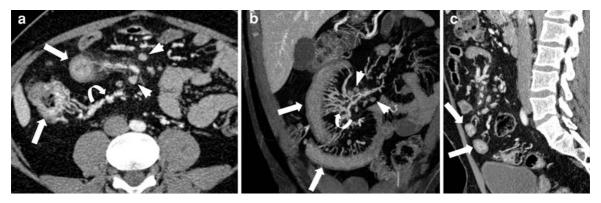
Contrast-enhanced axial (a), coronal (b) and sagittal (c) reformatted CT scans clearly showing bowel wall thickenings at the distal ileum (*arrows*). The thickened wall has a stratified appearance. Increased mesenteric vascularity known
